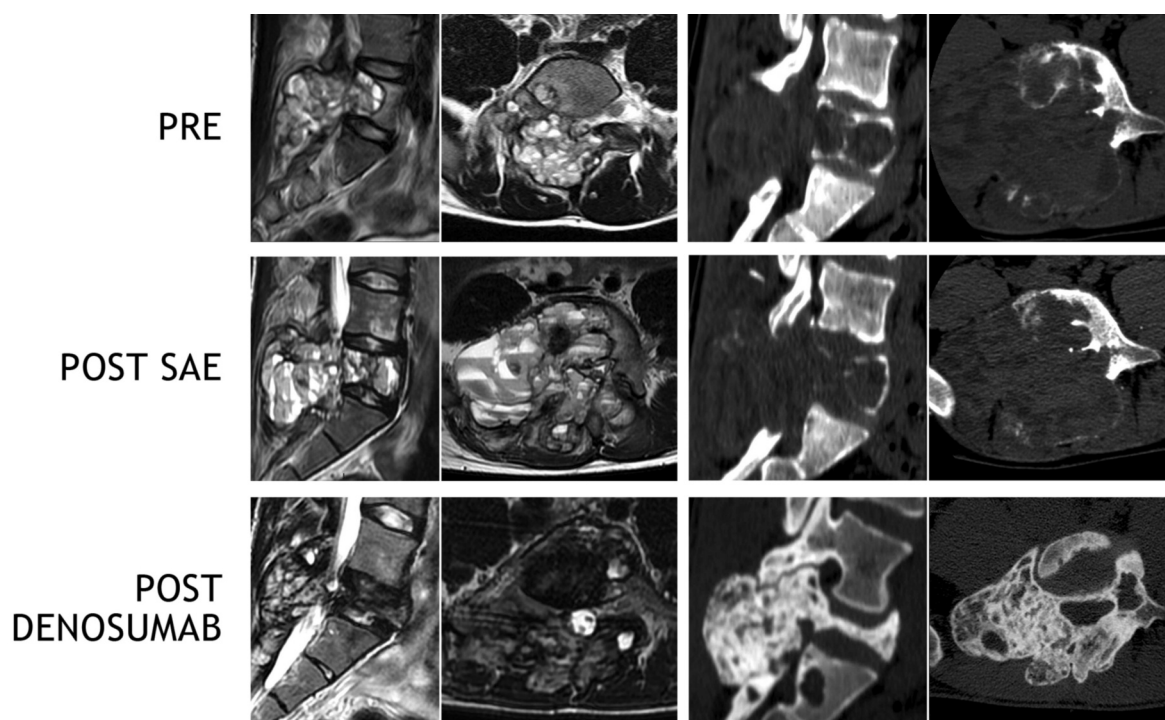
Imaging history of Case 2, reporting CT scan and MRI performed before ABC treatment, after embolization and after treatment with Denosumab.
